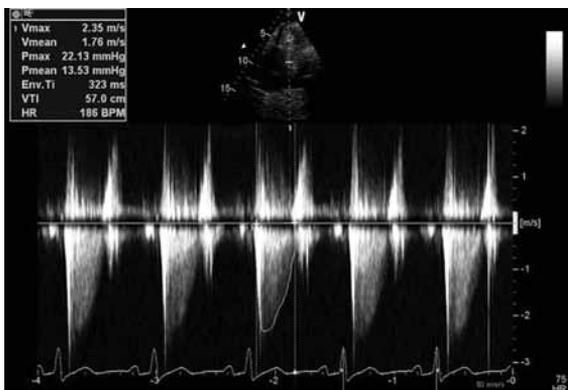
Transthoracic echocardiographic image showing a maximal resting outflow gradient of 22 mmHg.
